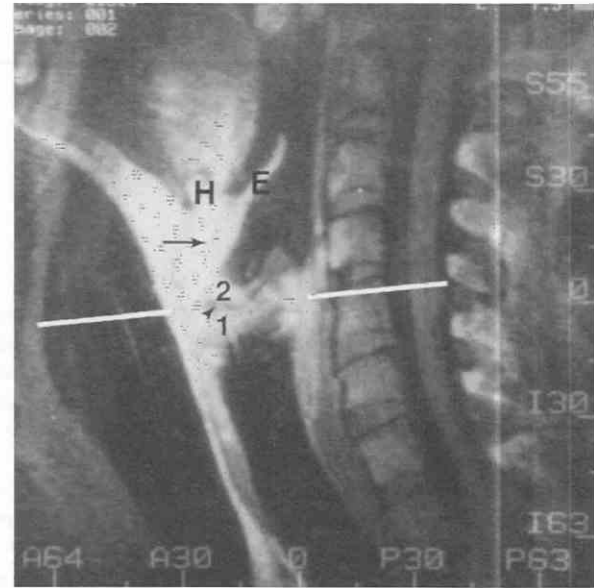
Sagittal T1-weighted MRI study. This sagittal slice is just off midline. The slice shows the anterior part of the true cord (1) and false cord (2) separated by the low signal intensity of the laryngeal ventricle (arrowhead). The axial image plane should be along the ventricle, as indicated by the white line. The preepiglottic fat is shown by an arrow. E, epiglottis; H, hyoid. (From Curtin HD: *MR and CT of the larynx*. In Thrall JH [ed]: *Current Practice of Radiology*, 3rd ed. St. Louis, Mosby-Year Book, 1994.)
